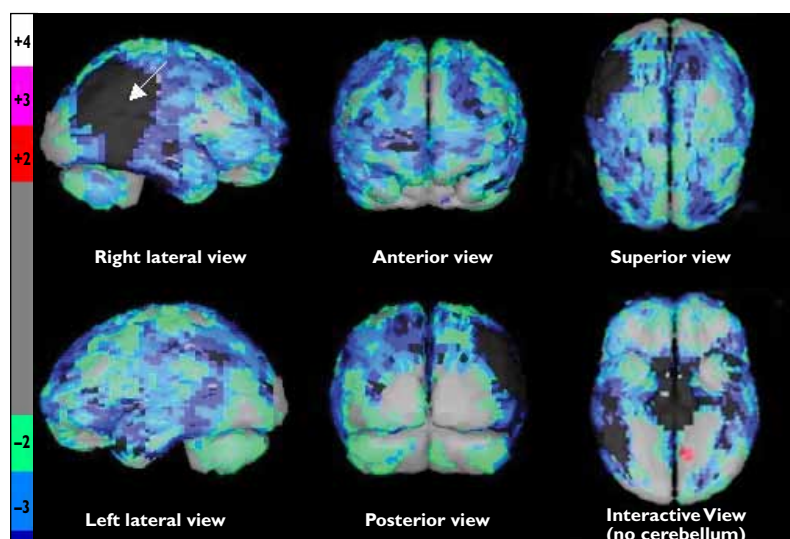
Talairach analysis of cerebral ethyl cysteinate dimer single-photon emission computed tomography (compared with computer-generated normal elderly database). The right posterior parietal lobe shows severe hypoperfusion (black-coloured area pointed out by white arrow) than for normal elderly, in addition to generalised mild-to-moderate cerebral hypoperfusion. The colour bar on the left is a scale representing the patient's cerebral perfusion with reference to the normal elderly database: grey colour denotes similar perfusion as the database; red, violet and white colours progressive hyperperfusion; green, blue, purple and black colours (not shown) progressive hypometabolism compared with the database
